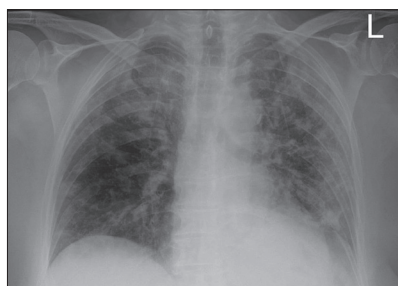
Case 1 – chest radiograph shows bilateral patchy pulmonary consolidations
